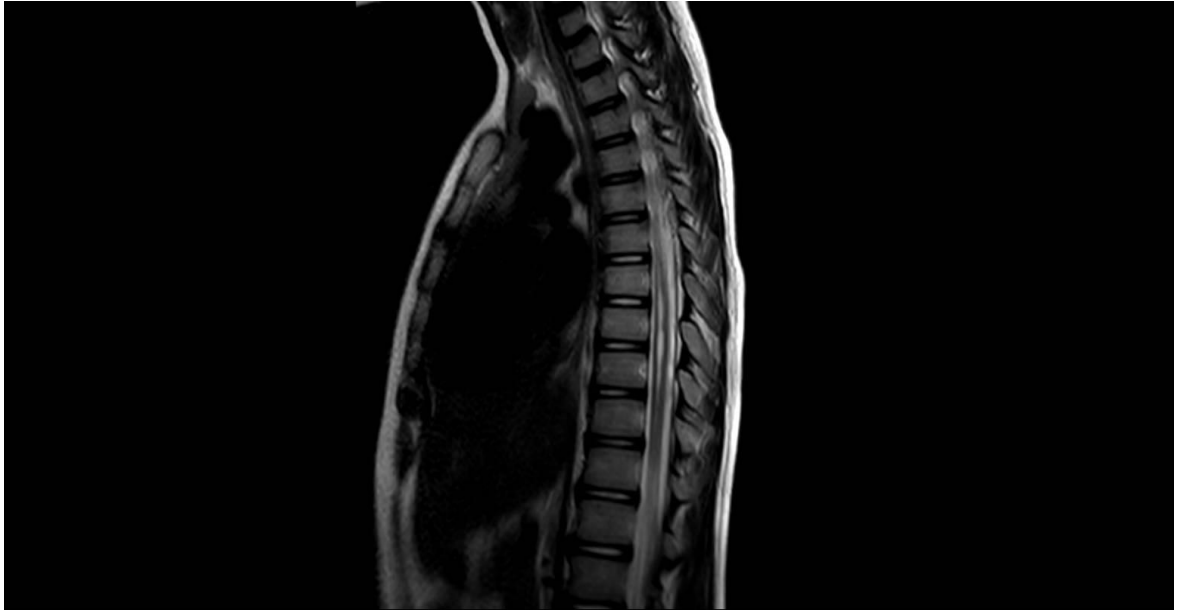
First MRI spine, sagittal T2 sequence showing syringomyelia of 2.7 mm in AP diameter (yellow arrow) extending from T4 to T12 (stars).
